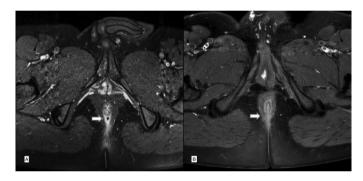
Pre-treatment (A) and post-treatment (B) contrast-enhanced magnetic resonance images
